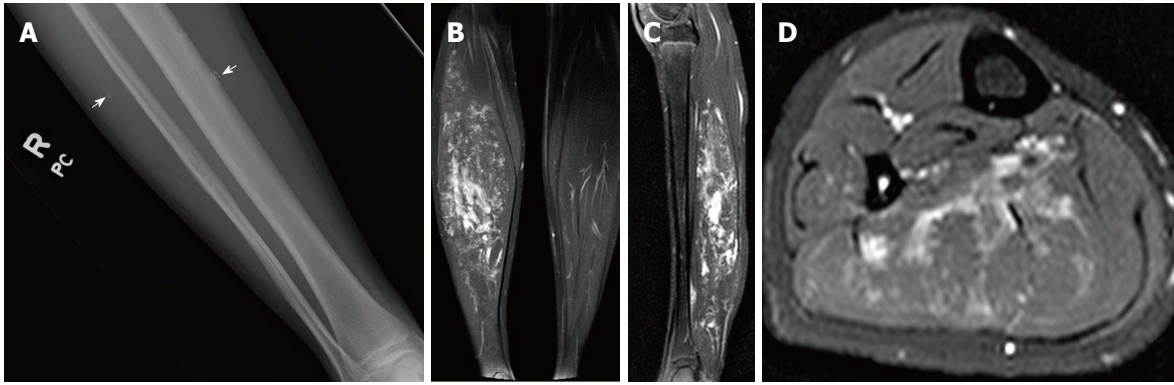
Low flow extratruncular venous malformation. Radiograph of the right lower leg (A) demonstrates phleboliths within the soft tissues (arrows). T2-weighted magnetic resonance images in the coronal (B), sagittal (C), and axial (D) planes demonstrate hyperintense signal within the gastrocnemius muscle due to infiltrative low flow extratruncular venous malformation.
